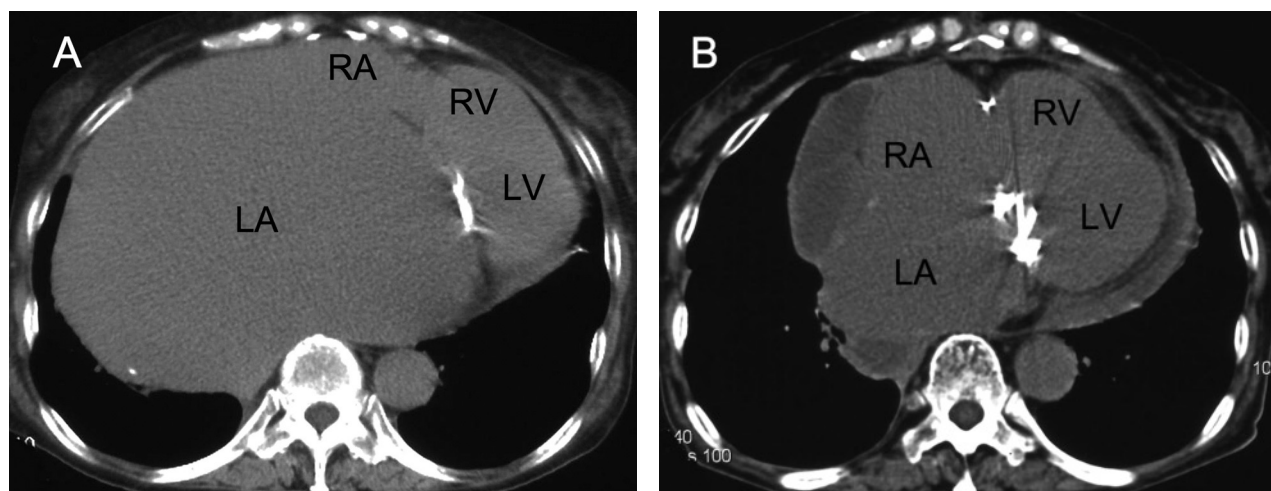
Computed tomography of the chest, showing left atrial volume reduction.
